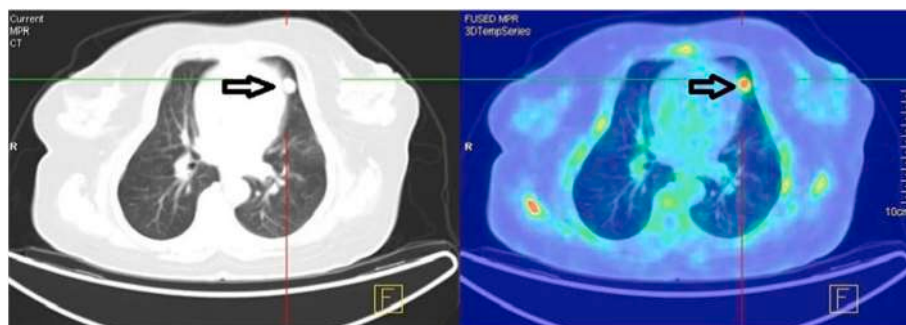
FDG PET-CT showing metabolically active left lingular nodule.
